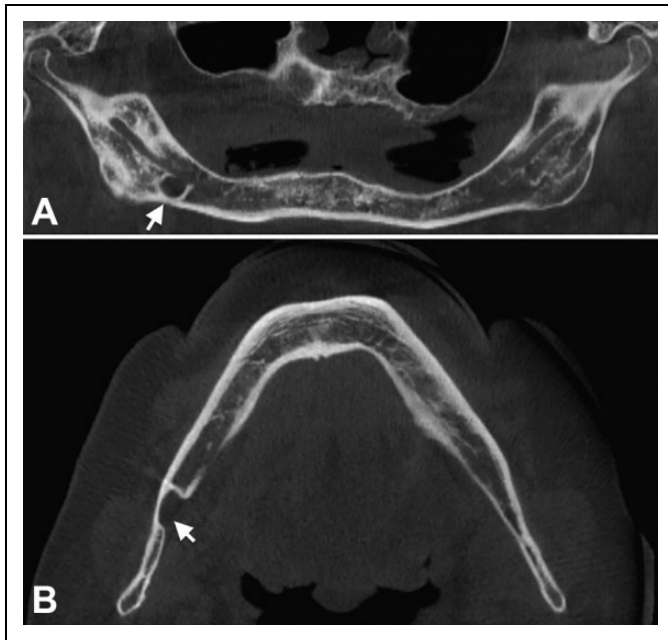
A Stafne bone cavity in a 73-year-old edentulous man. Reformatted thin-slice panoramic (A) and axial (B) cone-beam computed tomography images showing a well-defined, ovoid, radiolucent lesion in the region of the right submandibular gland fossa below the mandibular canal (arrows). The lesion is extending from the medial surface of the mandible and eroding the buccal cortex (arrow in B).
